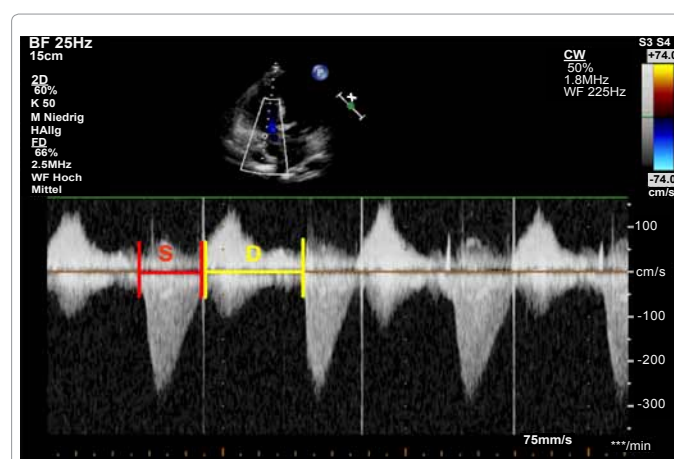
Apical 4-chamber view. Doppler-derived tricuspid regurgitation time (TR) interval ratio of systolic (S) duration to diastolic (D) duration (S/D). The ratio of S/D duration was calculated by dividing the duration of the TR spectral Doppler flow pattern by the time interval of the cardiac cycle that did not include TR. Systolic and diastolic duration using TR duration was measured by CW-Doppler from the apical 4-chamber view to calculate the S/D ratio. The red lines show the systolic duration, the yellow lines show the diastolic duration.
